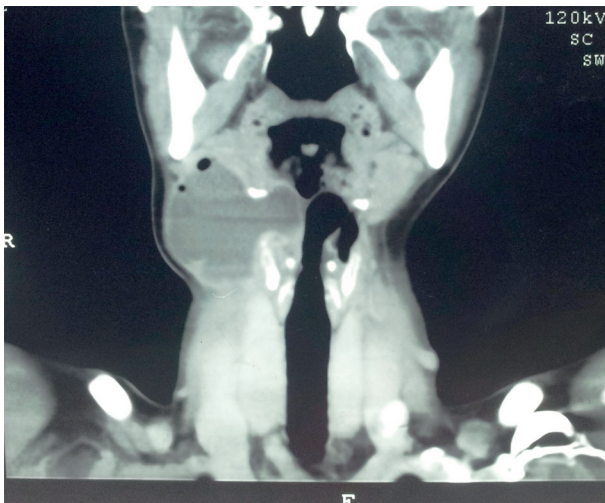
Axial computed tomography image of a typical unilateral combined laryngopyocele
